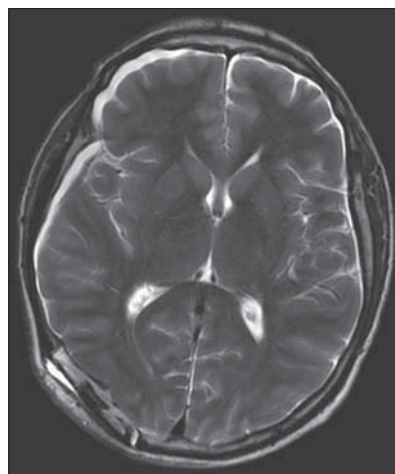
Delayed, magnetic resonance image, obtained 6 months after presentation shows dramatic normalization of the previously visualized ischemic changes corresponding to the patients' ultimately favorable outcome
